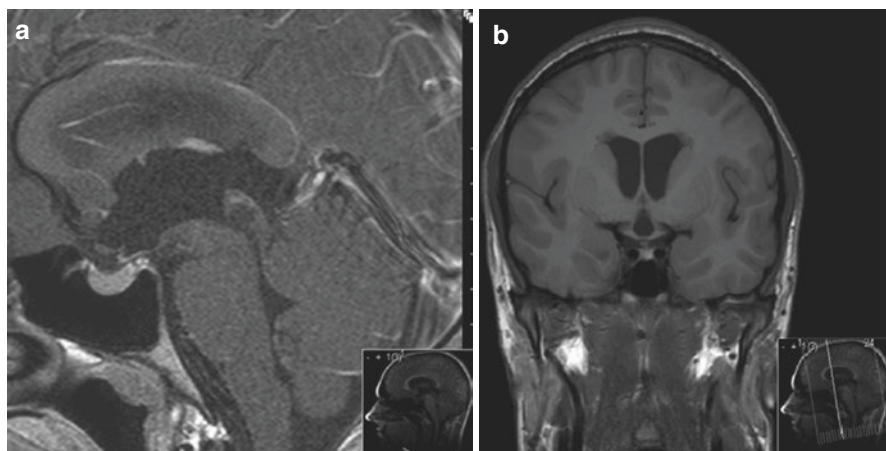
(a) T1 weighted sagittal MRI scan showing enlargement of the third and lateral ventricles and a non-enhancing lesion of the tectal plate. Coronal scans (b) show the base of the third ventricle prolapsing into the suprasellar cistern
